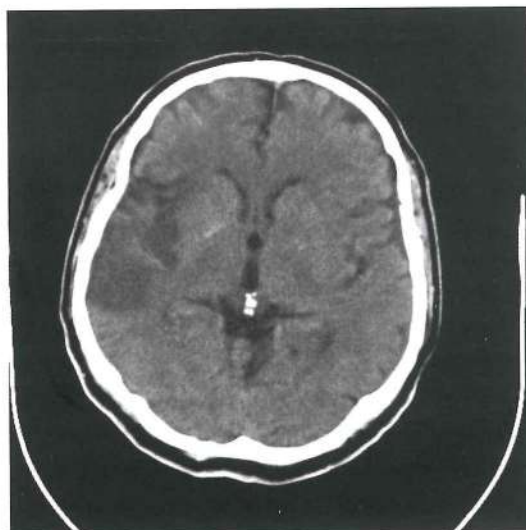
Ischemic stroke in temporoparietal region (by computed tomography) in patient with Wernicke's aphasia
